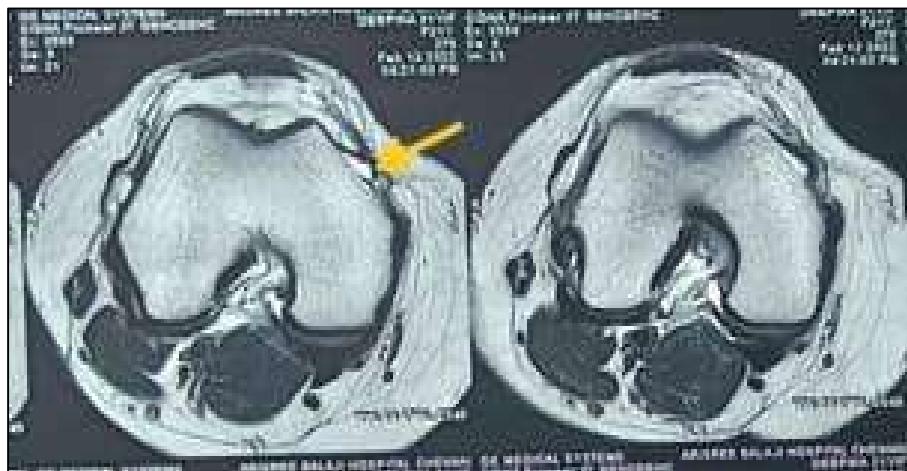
MRI right knee-Axial knee cut demonstrating hyper intense signal shift over the femoral condyle at the MPFL insertion site
